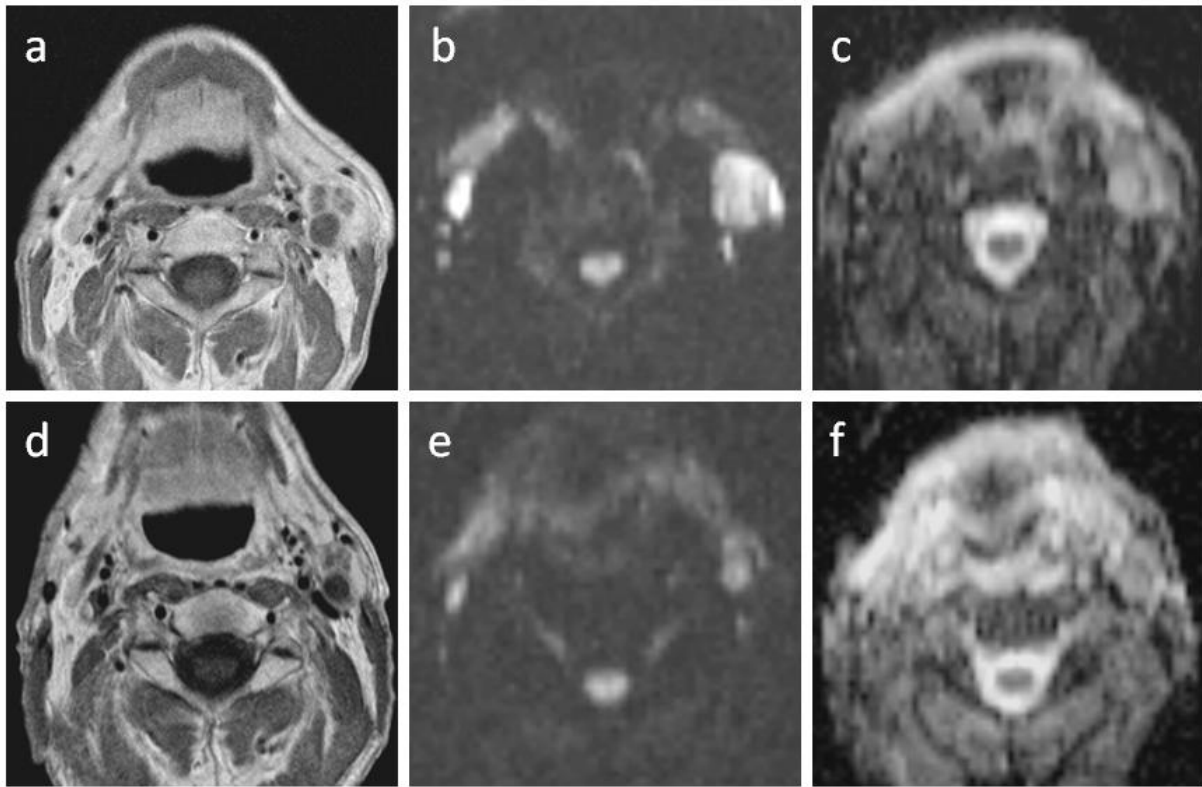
Upper row: patient with left tonsillar cancer (image not shown) presents with nodal metastasis in left level 2 on (a) contrast-enhanced T1-weighted TSE image, (b) b1000 diffusion-weighted image, and (c) ADC-map prior to therapy.
